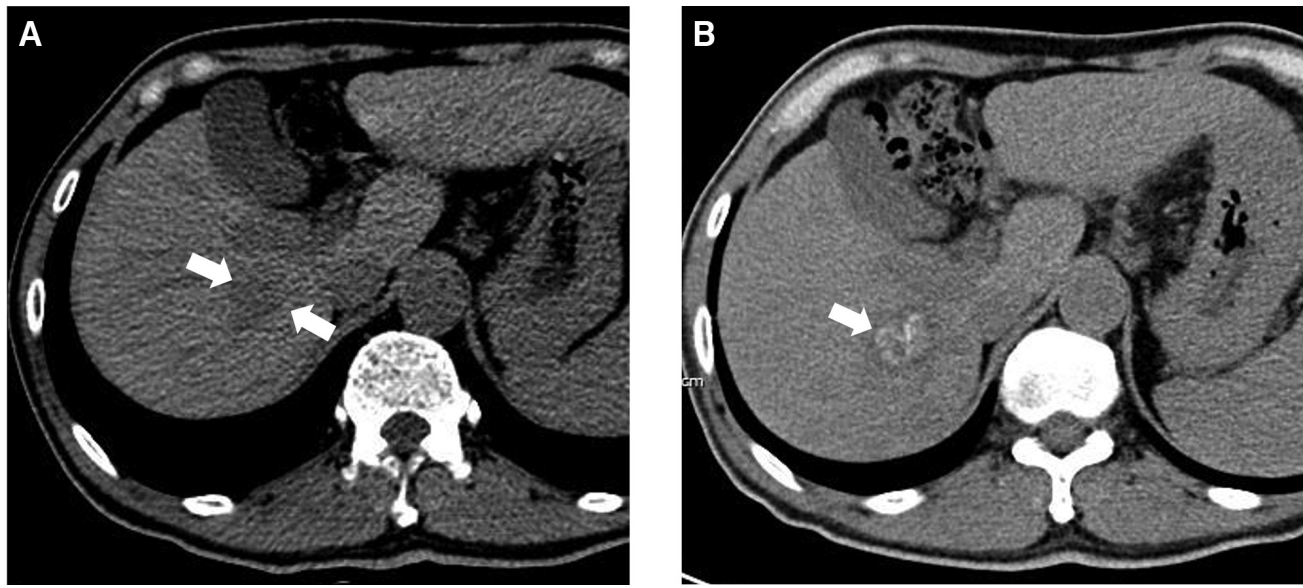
A 58-year-old man with hepatocellular carcinoma. (A) Non-contrast axial CT image prior to radioembolization shows a 3 cm mass (arrows). (B) Non-contrast axial CT image one month after radioembolization shows diffuse calcifications (arrow) within the tumor.
